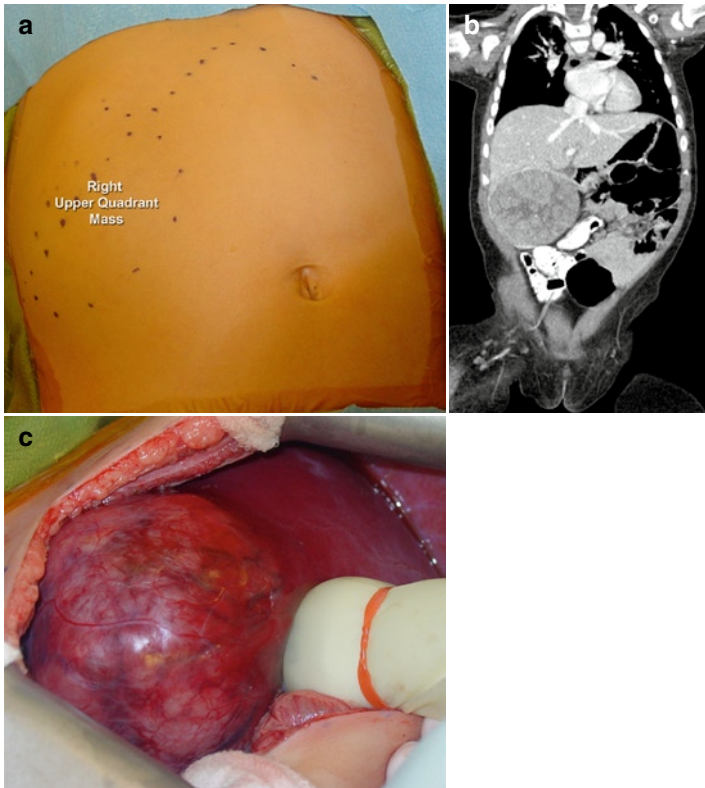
Six-month-old with (a) large right upper quadrant mass, (b) arising from the liver on CT scan, and (c) resected with intraoperative ultrasound guidance.
